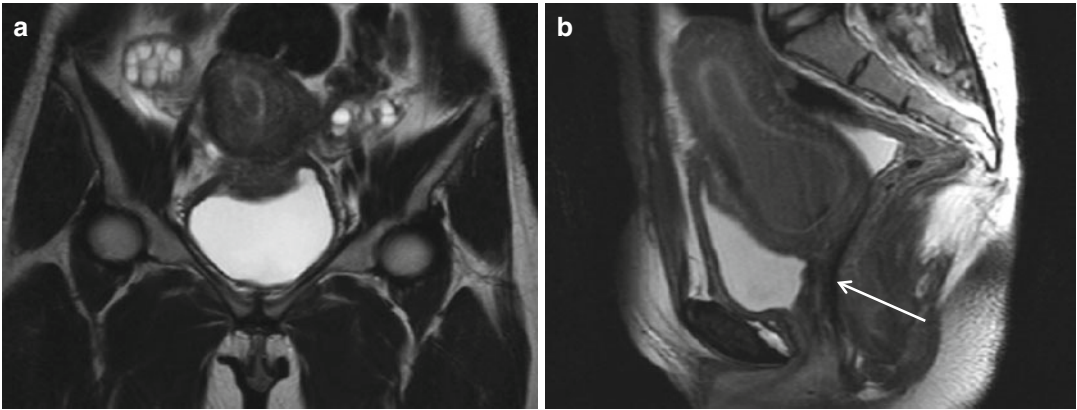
Vaginal agenesis (Ia). Fast spin-echo T2-weighted images on coronal (TR/TE 3310/94) (a) and sagittal plane (TR/TE 4070/94) (b) show normal uterus with cervix and no vaginal cavity (*arrow* in b)
